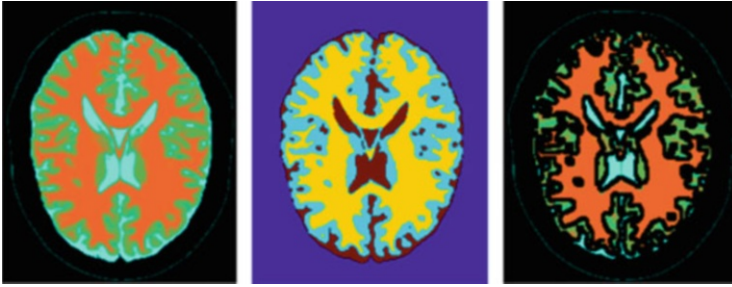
The original MRI after preprocessing (*left*), the false-colored cluster labels (*middle*) and the resulting segmented image (*right*) [7]
